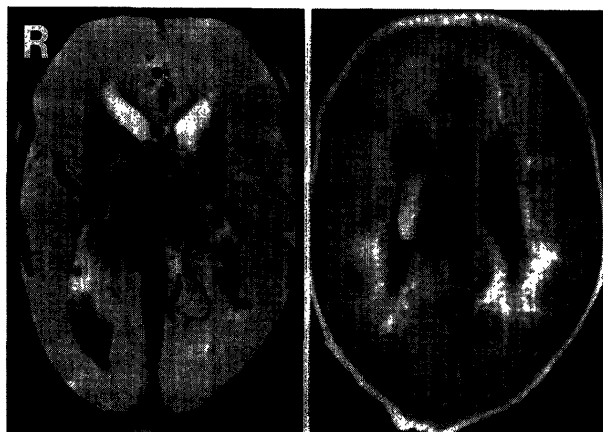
left*: T₁-weighted MR image revealing the aneurysmal sac and straight sinus as a signal void, and intraventricular hemorrhage. *right*: T₂-weighted MR image clearly showing the subependymal hemorrhage.
